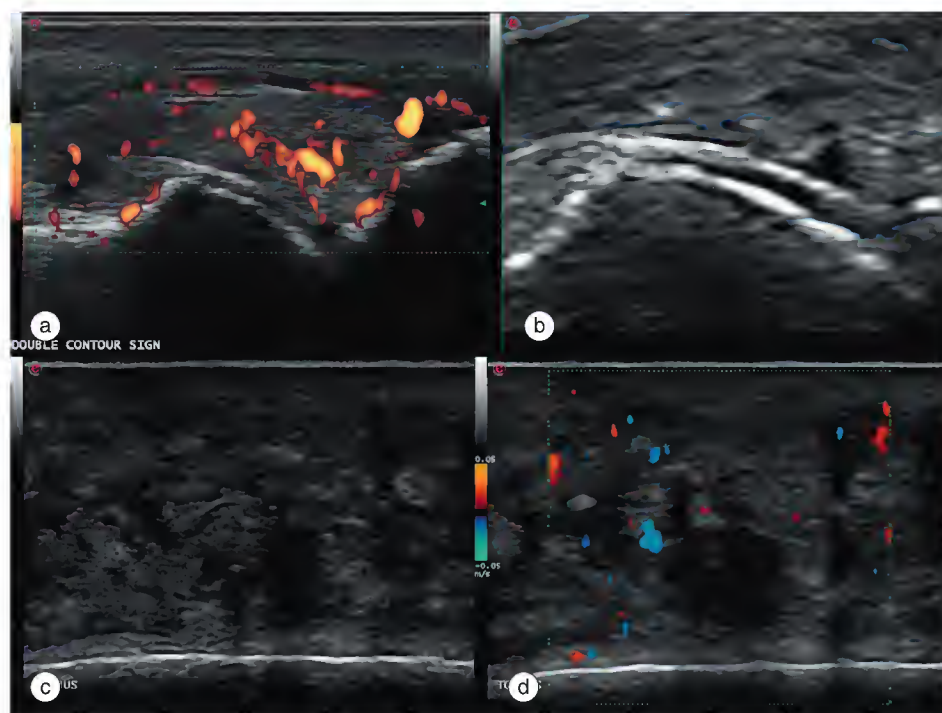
Gout. (a) Acute gout of the first metatarsophalangeal (MTP) joint. Ultrasound shows acute inflammation with heterogeneous enlargement of the joint capsule and increased power Doppler signal due to tophaceous material and synovitis. (b) Double contour sign of gout is the appearance of a hyperechoic line superficial and parallel to the bone cortex caused by urate crystal deposition on the surface of cartilage. There are also focal hyperechoic speckles in the joint space caused by urate crystal aggregates. (c) Mixed hyperechoic and hypoechoic appearances of tophus adjacent to the first MTP joint. (d) Color Doppler ultrasound of tophus shows it to be hypervascular in this case of acute gout.
